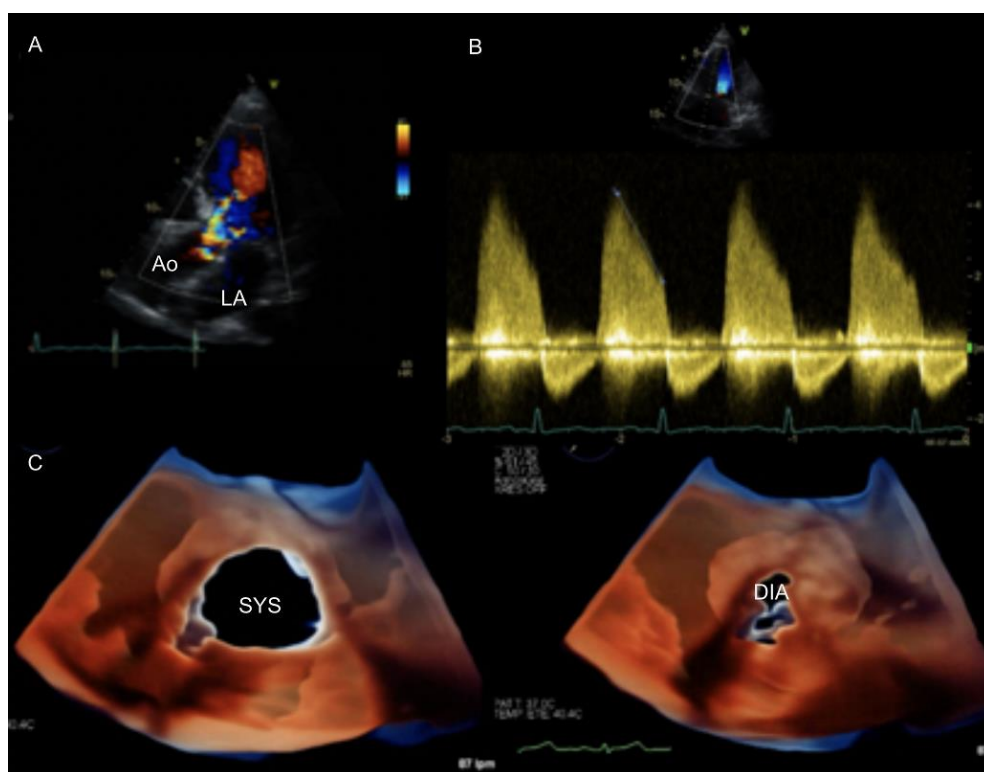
2D TTE with continuous Doppler and 3D TEE with color
